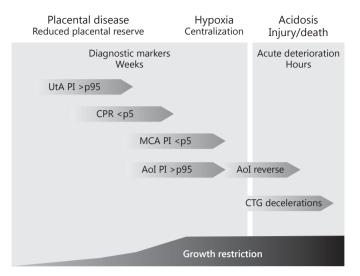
Fetal deterioration and monitoring in late-mild FGR. Placental disease is mild and UA Doppler values are not elevated above the 95th centile. The effects of fetal adaptation are best detected by the CPR, which can pick up mild changes in the AU and MCA Doppler. An important fraction of cases do not progress to baseline hypoxia so that they remain only with abnormal CPR. Once baseline hypoxia is established, placental reserve is minimal and progression to fetal deterioration may occur quickly, as suggested by the high risk of severe deterioration or intrauterine fetal death after 37 weeks in these cases, possibly due to a combination of a higher susceptibility to hypoxia of the term-mature fetus and the more common presence of contractions at term (see text for abbreviations).
